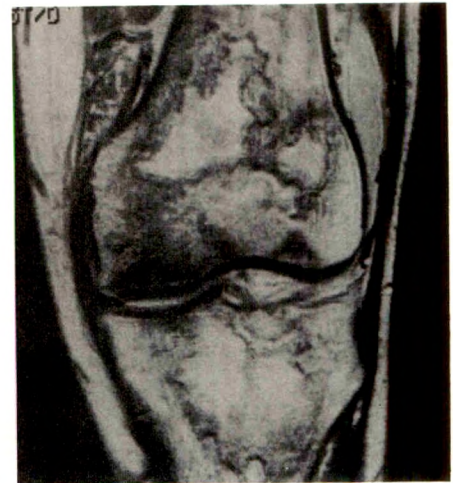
Immature bone infarct in a patient with acute lymphocytic lymphoma on chemotherapy, who presented with knee pain. Coronal MR image (2000/40) shows numerous lesions in both femur and tibia with high-signal centers and low-signal serpentine rims characteristic of bone infarcts. Only ill-defined, patchy lucencies were noted on conventional radiographs.
